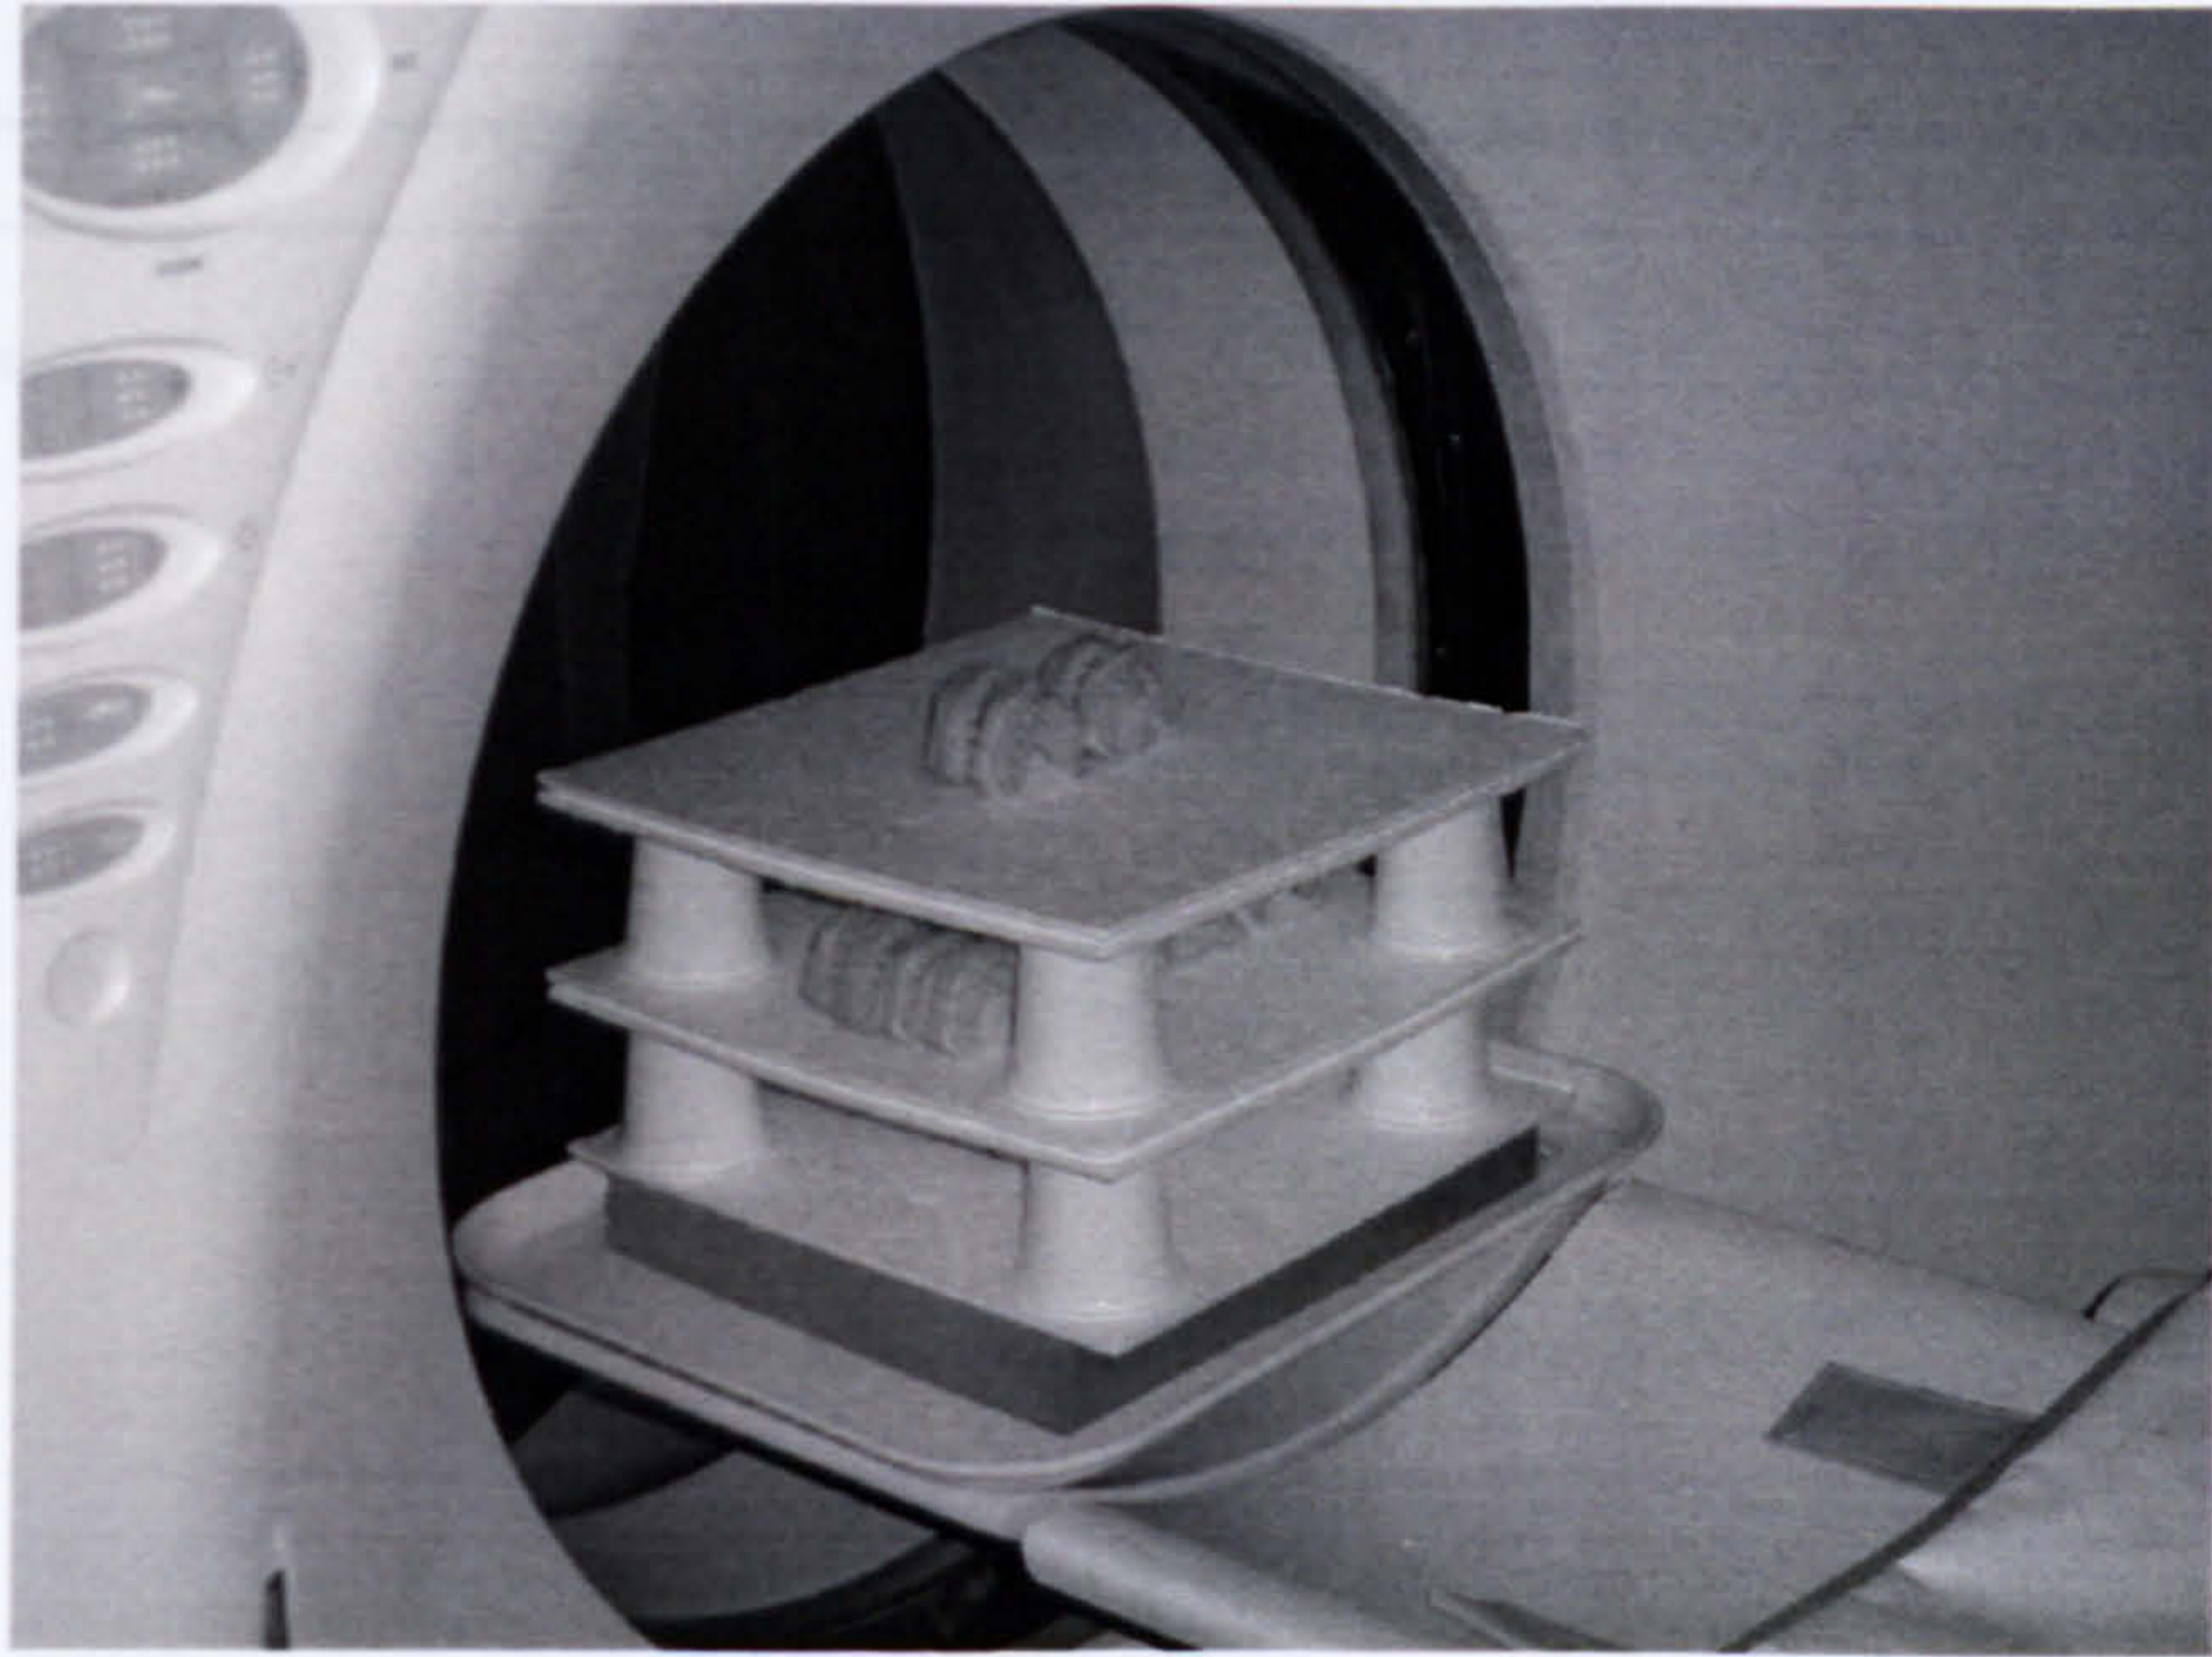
Study models in CT scanner
